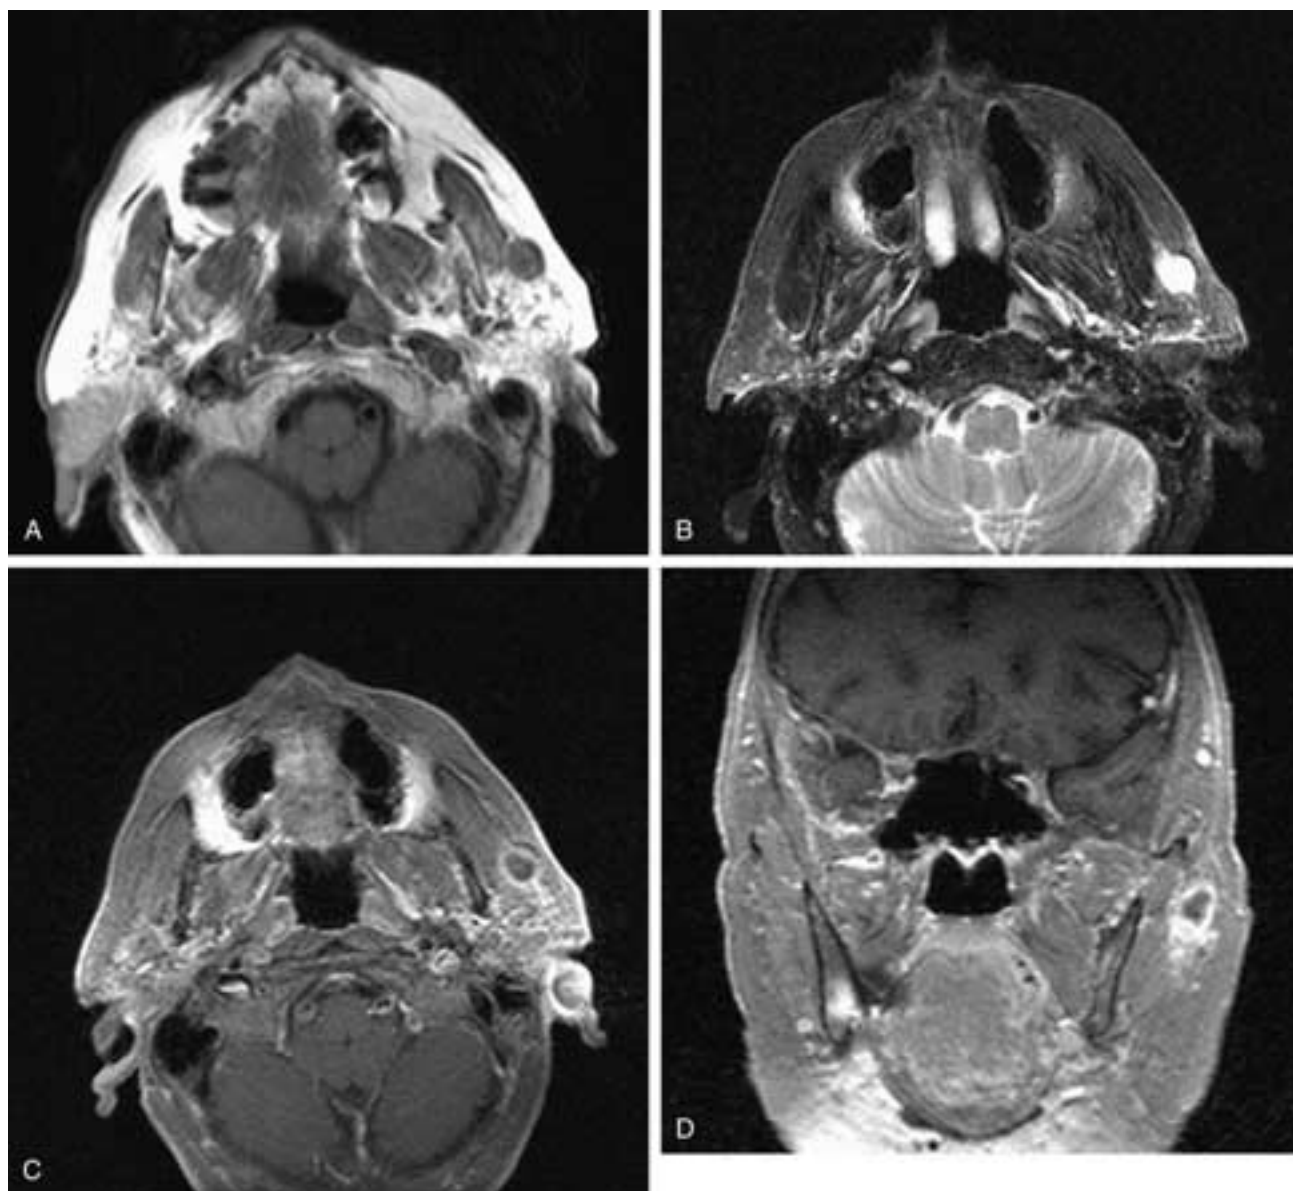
Axial T1-weighted (A), T2-weighted (B), and axial (C) and coronal (D) T1-weighted, fat-suppressed, contrast-enhanced MR images show a well-defined mass in the superficial left parotid gland. It has low T1-weighted and high T2-weighted signal intensity and is partially cystic, as seen after contrast administration. The finding might suggest a benign lesion such as a Warthin's tumor. This patient had a low-grade MEC.
